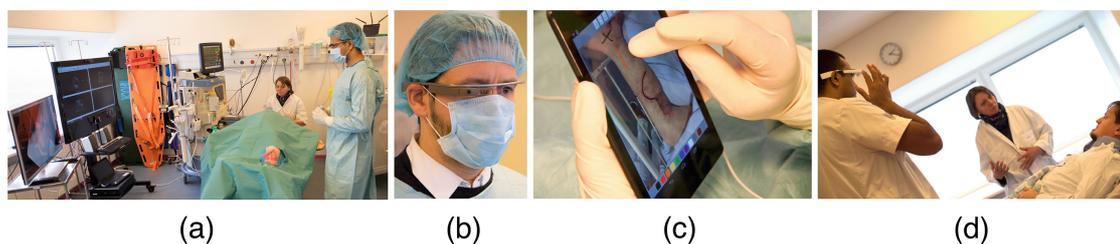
(a) A surgeon uses the WPA for touch-less interaction with X-rays and MRIs. (b) The local surgeon sees the visual guidance on the HMD in real-time. (c) A remote surgeon uses a tablet device to provide guidance to the local surgeon. (d) A surgeon uses the WPA to browse EPR and X-rays in the ward round scenario.
